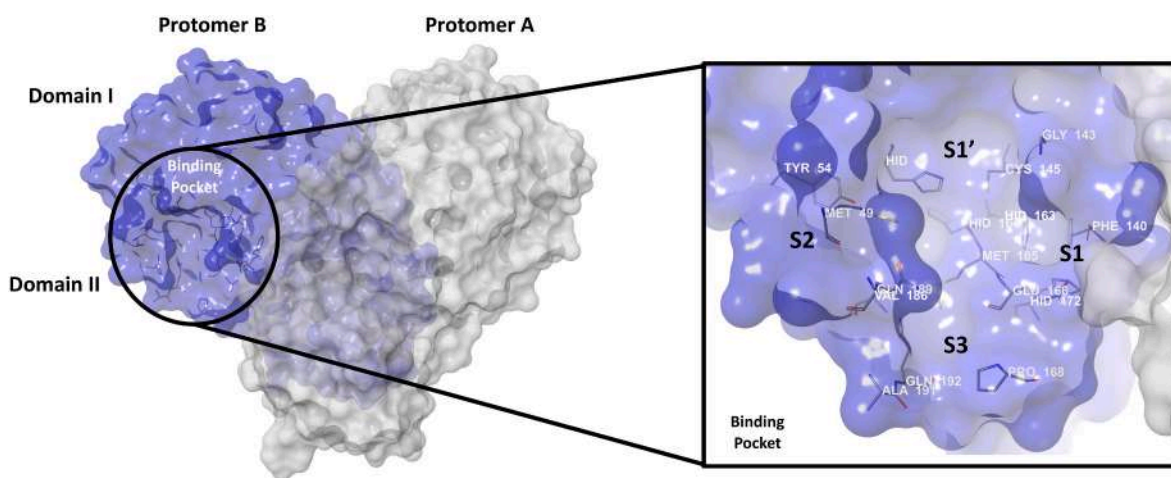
X-Ray structure of dimeric SARS-CoV-2 M^{PRO} and focus on the catalytic site, with the four region S1, S1', S2 and S3/S4 highlighted (PDB code 6Y2F) [38].
